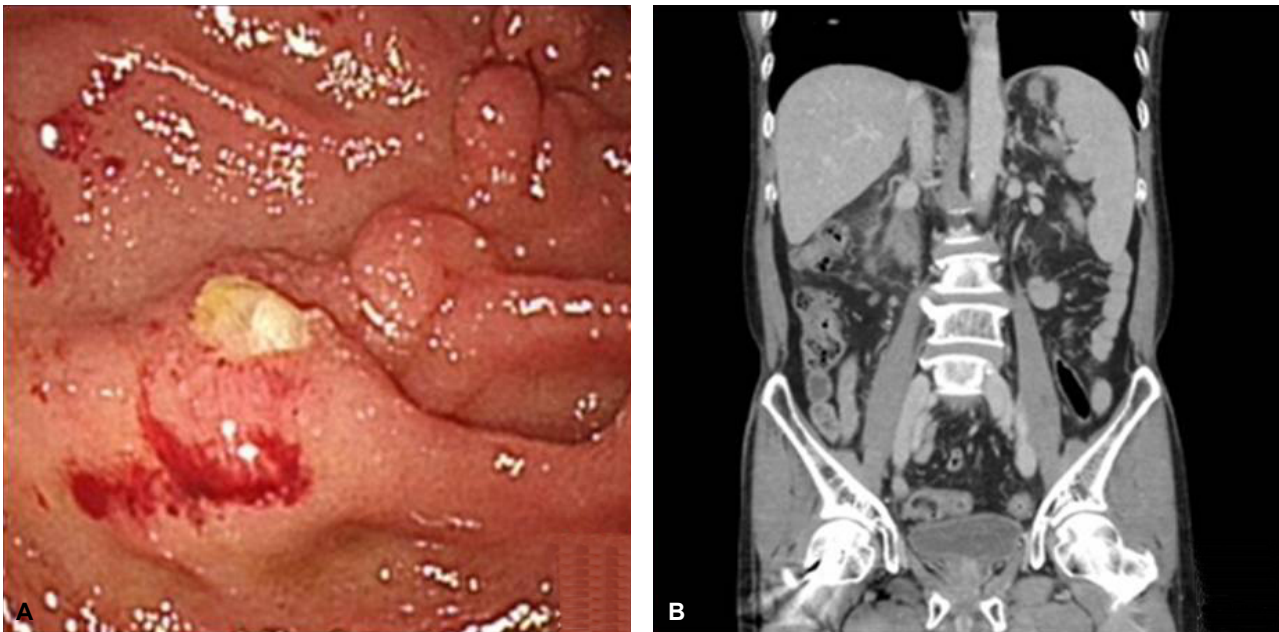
Results of follow-up endoscopy and CT performed 6 months after EIS. (A) Endoscopy revealed more collapsed varices with small yellow plaques on the postbulbar portion of the duodenum. (B) Abdominal CT disclosed collapsed and greatly decreased portosystemic venous collaterals in the retroperitoneum of the paraduodenal space.
